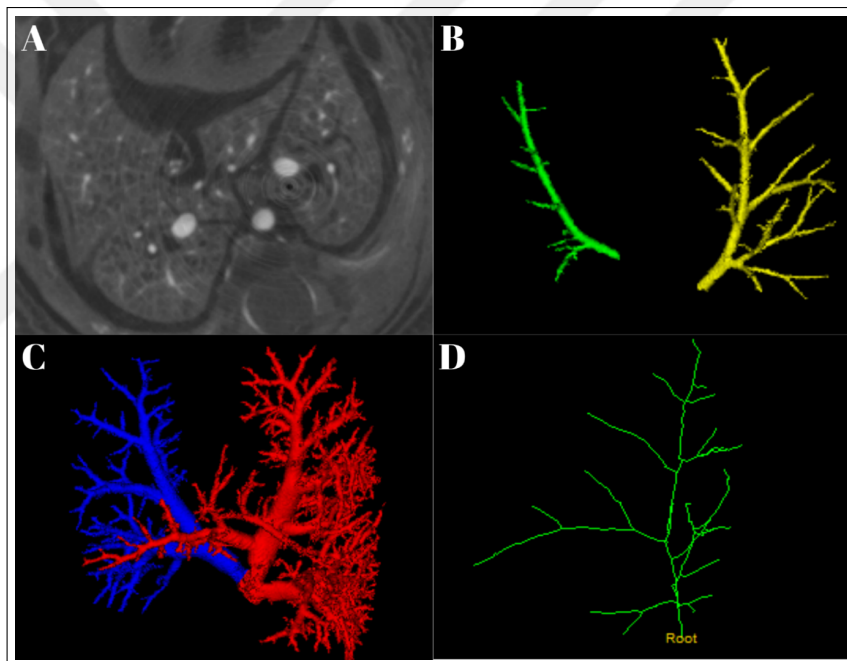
A: Cropped CT lung image, B: Segmented left and right arteries, C: Segmented left and right veins, D: Skeletonized right artery.
